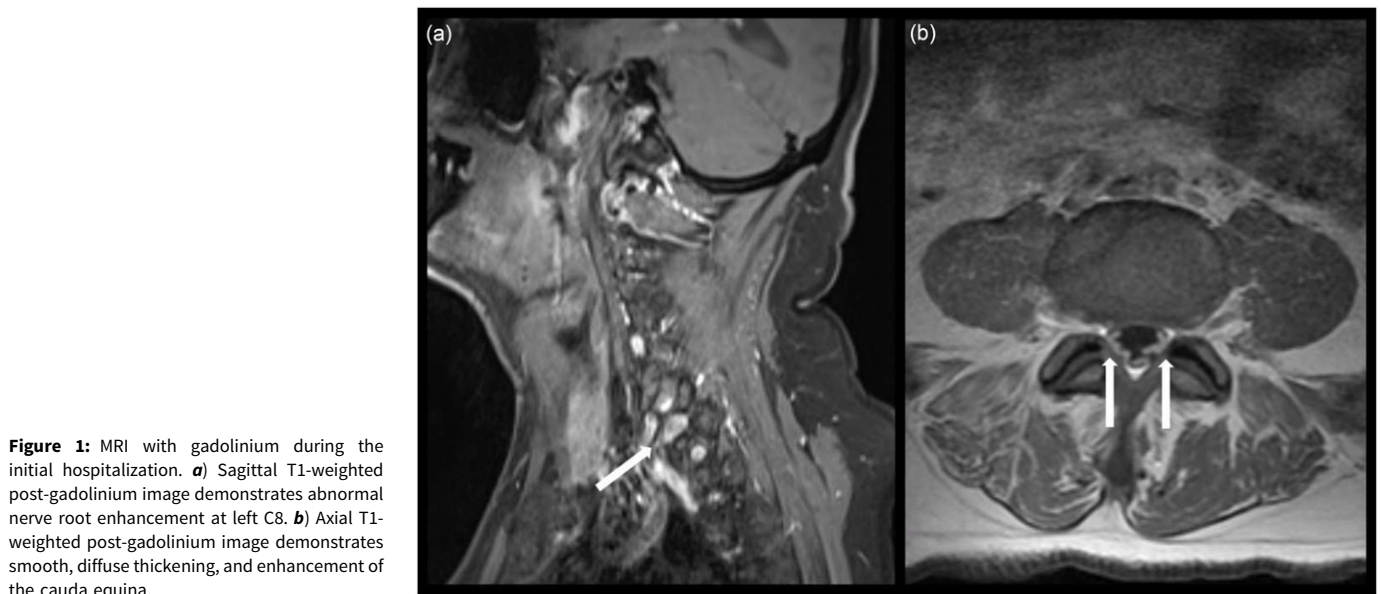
MRI with gadolinium during the initial hospitalization. a) Sagittal T1-weighted post-gadolinium image demonstrates abnormal nerve root enhancement at left C8. b) Axial T1-weighted post-gadolinium image demonstrates smooth, diffuse thickening, and enhancement of the cauda equina.
